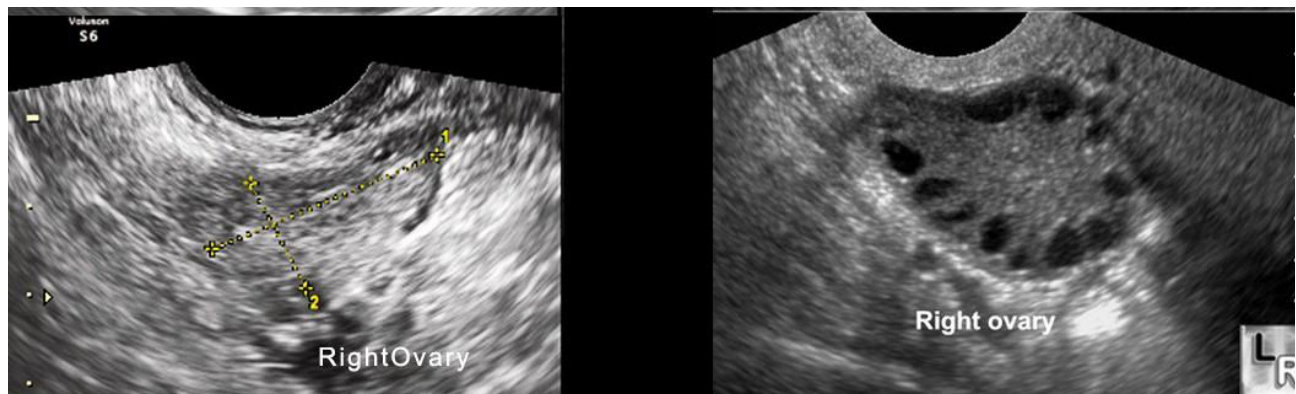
Sonography of the patient
